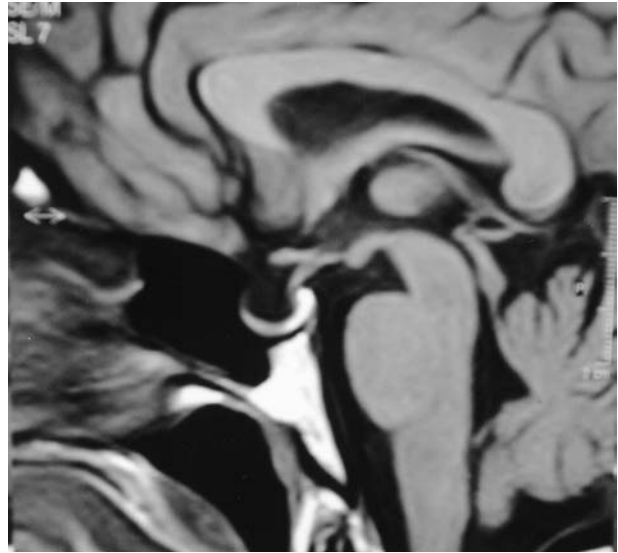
Sagittal section of a T1-weighted magnetic resonance image showing an empty sella.
